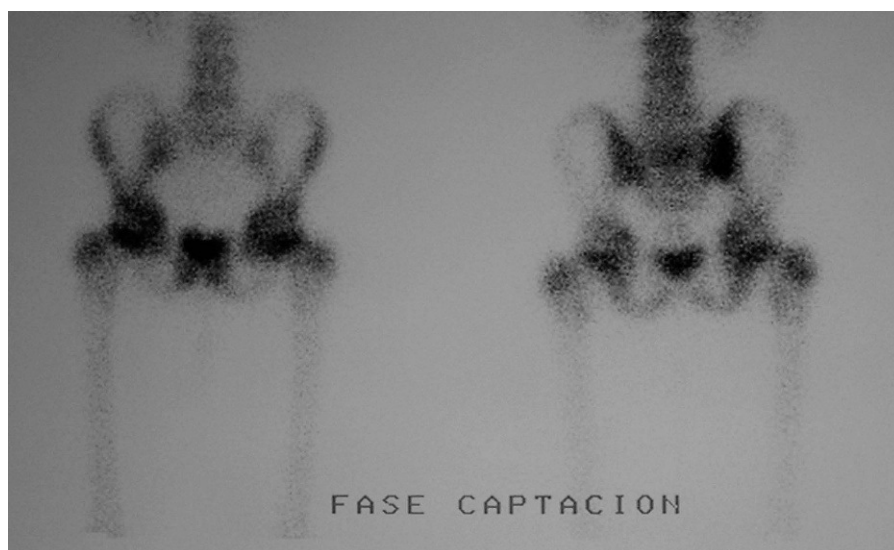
Uptake phase of Tc99 scintigraphy bone scan. The late phase shows an abnormal increased uptake, homogeneous and with notable intensity in the right sacroiliac joint; there is also an increased pattern of bone metabolism, consistent with sacroiliitis, with a high degree of inflammatory activity. Quantification by pixels with respect to the sacrum of 1.5 (normally less than 1.3).
